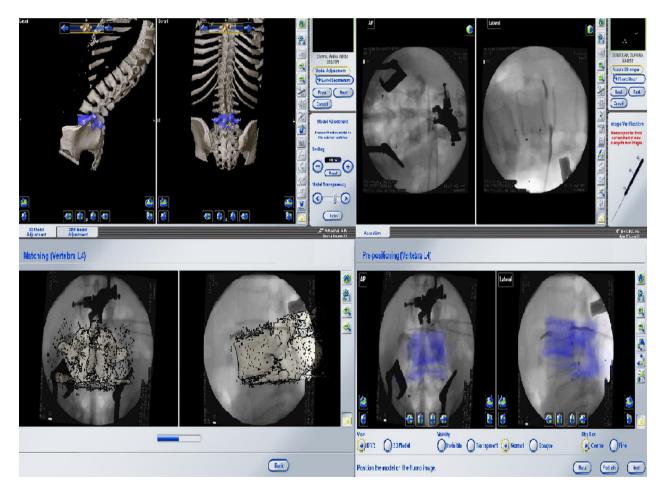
Fusion between the intraoperative fluoroscopy and a 3D model of a vertebra (based on the CT scan) and subsequently registration of the defined vertebra.
